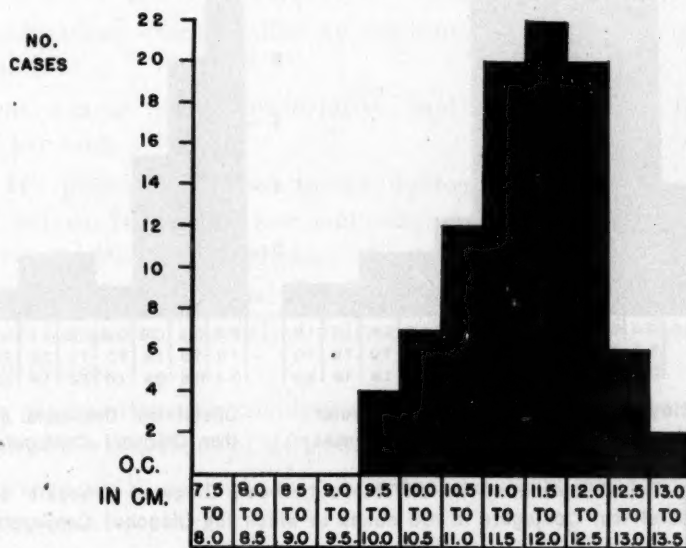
I Distribution of obstetrical conjugate (x-ray) in 92 cases in which diagonal conjugate was measured at 11.5 cm., or more. (after Dippel).
